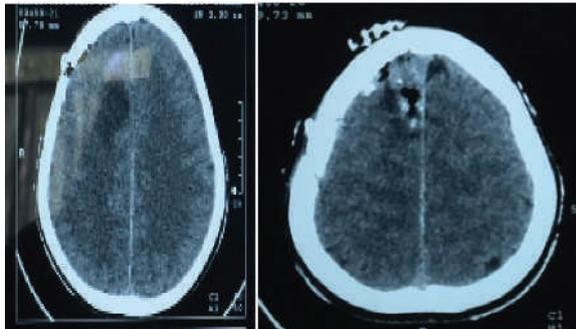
Post-operative CT brain of anterior falxine meningioma showing complete excision of the tumor with post-op changes.
